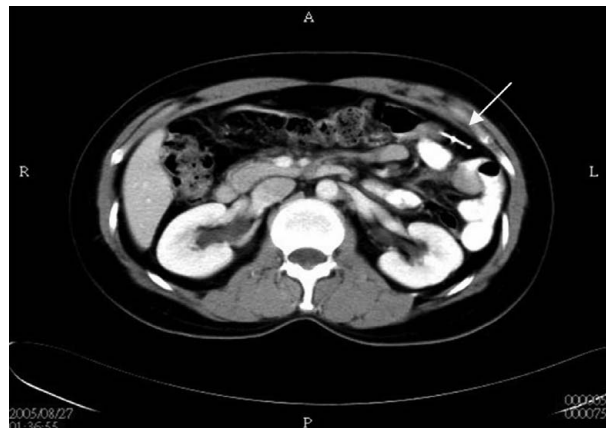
Computed tomography shows that the object (arrow) lies above the intestines at the level of the junction between the thoracic and lumbar spines.
